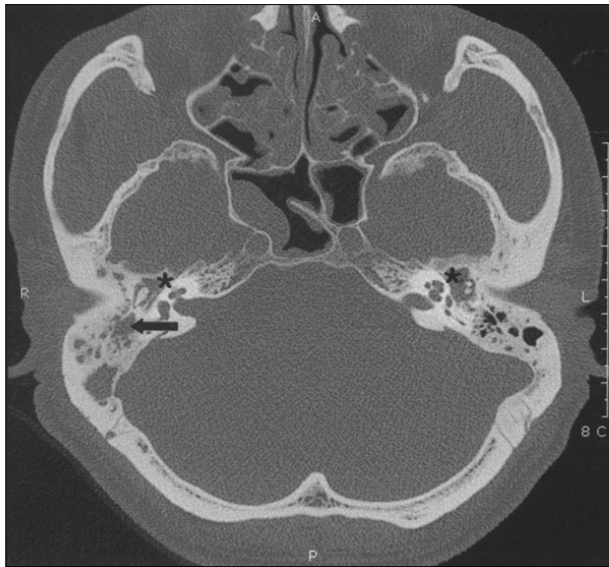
Axial CT scan of the temporal bone showing soft tissue density of middle ear (astro) and mastoid cavity (black arrow).
